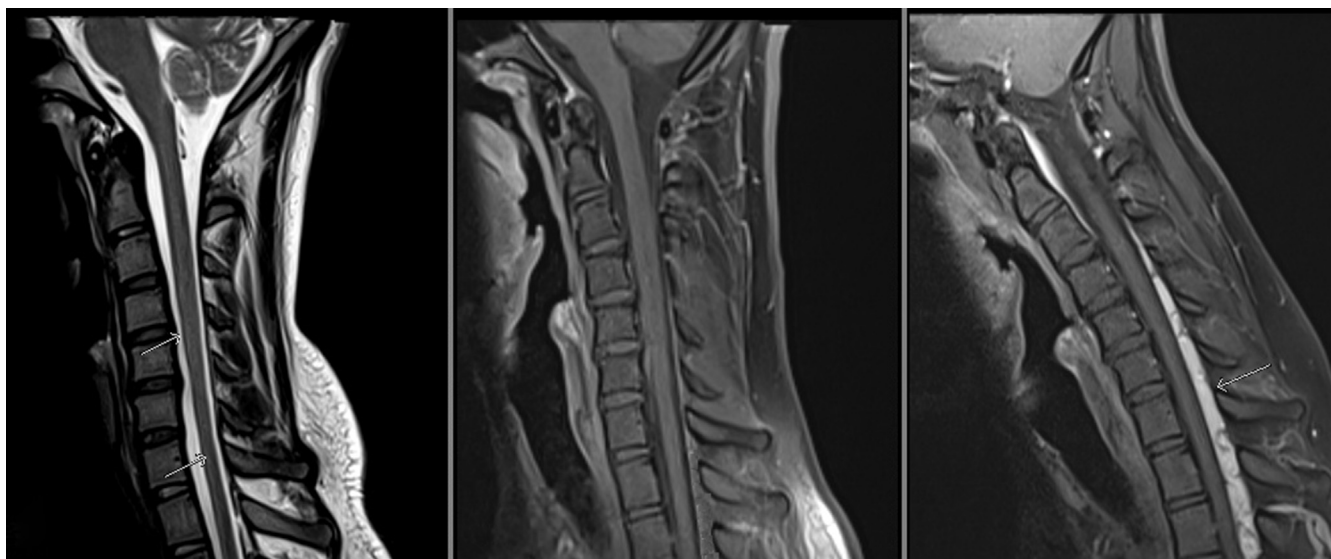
Magnetic resonance imaging (MRI) of the cervical spine: (Left) Sagittal T2 sequence demonstrating subtle thinning (arrows) and mild hyperintensity of the cord at the C5–C7 levels. (Middle) Gadolinium-enhanced sagittal T1 sequence in neutral position not showing any abnormality. (Right) Flexion MRI demonstrating a prominent posterior epidural space with enhancement in the dorsal aspect of the spinal canal (arrow) from C5 to the upper thoracic levels.
